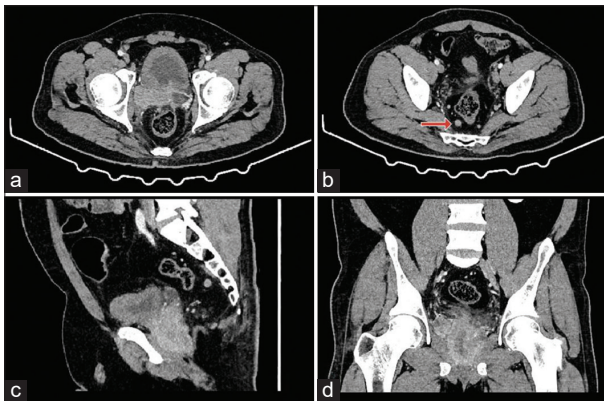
(a, b, c and d) Contrast-enhanced computed tomography of the abdomen and pelvis showed an enlarged prostate gland with a multilobulated appearance involving all zones, predominantly the peripheral zone, measuring 7.3 × 7.4 × 9.1 cm (volume: 255 cm³), with invasion of seminal vesicles, urinary bladder, posterior urethra, anterior rectal wall, and right lateral pelvic wall. (b) Multiple variable sized lymph nodes noted in peri-rectal, pre-sacral, obturator, and external iliac regions (Denoted by arrow)
